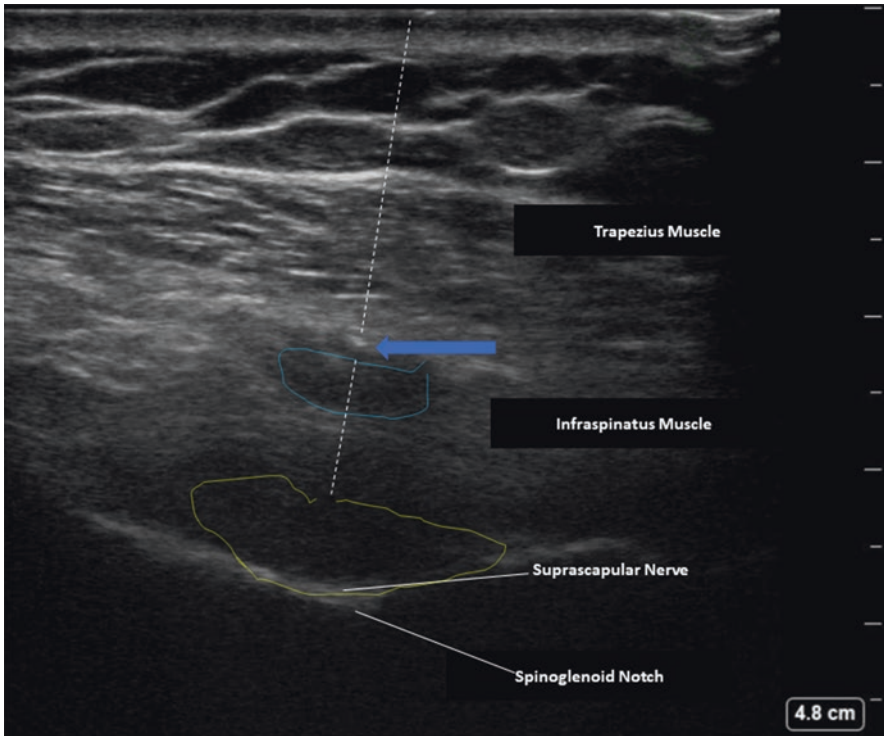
Ultrasonogram of the suprascapular nerve block, superior distal approach. Dashed line represents out of plane the needle trajectory. Image—courtesy of Dmitri Souza
